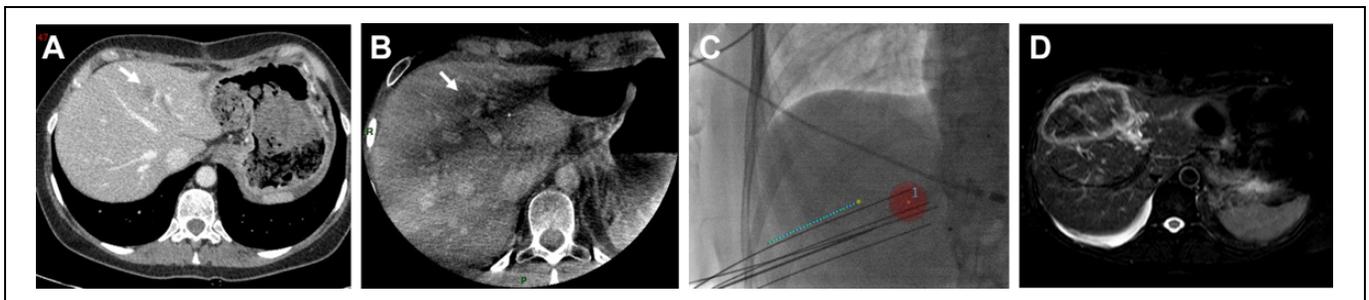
Irreversible electroporation ablation of a hypovascular tumor not visualized with US using 3D-VTFD from segmented CBCT acquired at the portal phase of liver enhancement after the intravenous injection of iodinated contrast medium. A, Axial pretherapeutic CT of the liver acquired at the portal phase after the intravenous injection of iodinated contrast medium revealing a small subcapsular hypovascular nodule in segment 3 (arrow). B, Cone beam CT acquisition 70 seconds after the intravenous injection of iodinated contrast medium at a speed of 20°/s shows the tumor (C) that is segmented for 3D-VTFD used to insert 4 probes. D, One month after the procedure, axial T2-weighted MR images reveal an iso-intense area surrounded by a hyperintense rim encompassing the tumor boundaries and indicative of a complete response. 3D-VTFD indicates 3D virtual target fluoroscopic display; CBCT, cone beam CT; CT, computed tomography; MR, magnetic resonance.
